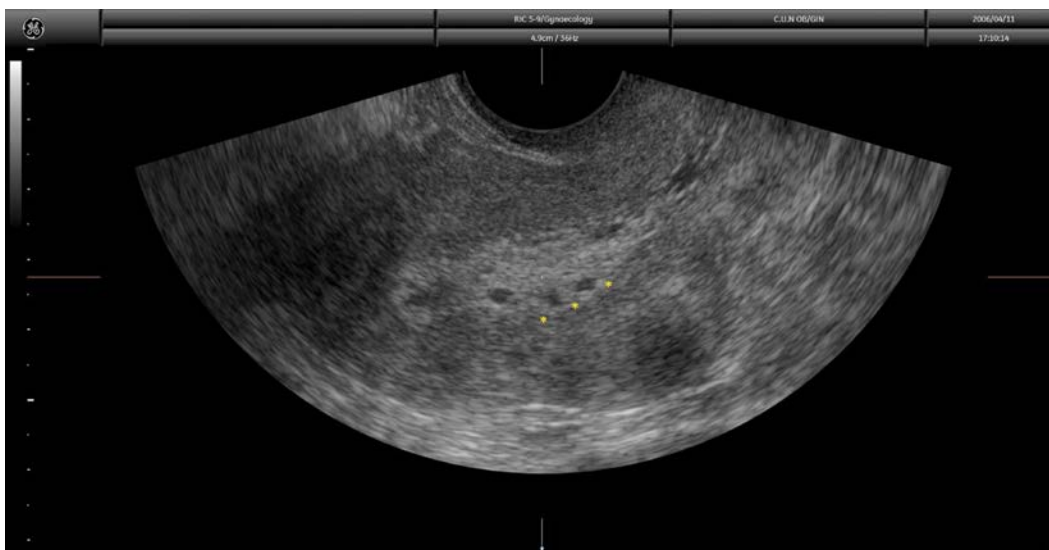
Transvaginal ultrasound showing a thickened endometrium in a 59-year-old woman presenting with postmenopausal bleeding. We observe some cystic areas, and it seems that the posterior endometrium is protruding into the myometrial wall (*) suggesting some degree of infiltration. Endometrial sampling proved the existence of a G2 endometrioid carcinoma.
